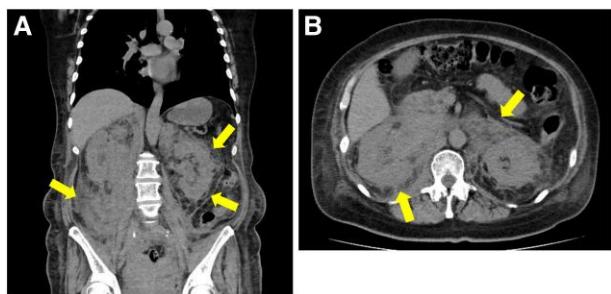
Computed tomographic scan at the first outpatient visit. Coronal (A) and axial (B) planes of the abdomen showing bilateral perirenal tumors (arrows).
